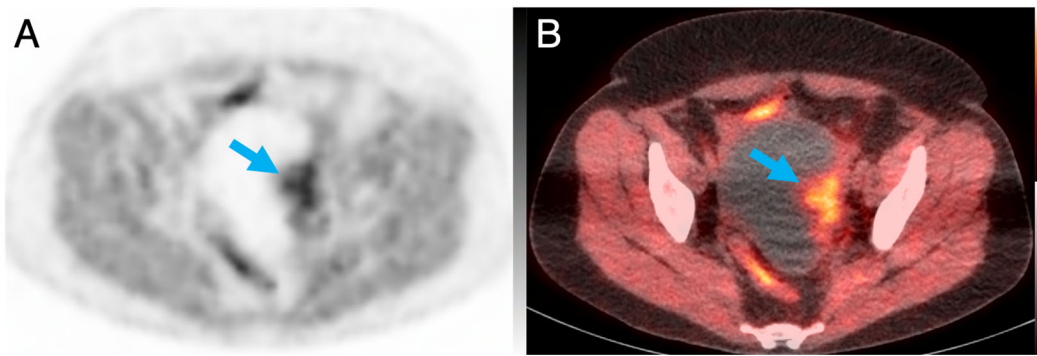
Patient 4's PET (A) and fused PET/CT (B) images 108-minutes post-injection with blue arrow indicating tumor with SUV_{max} of 5.6 g/mL. Scaled 0-5 g/mL SUV and -160 to +240 HU CT.
